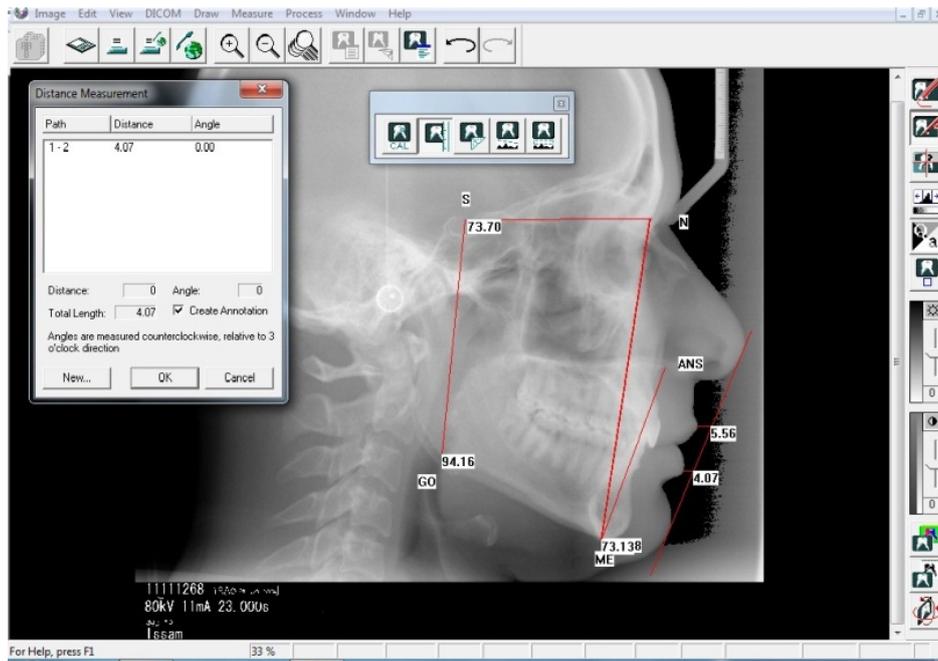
Linear cephalometric analysis of original size radiographic digital image (100%).
